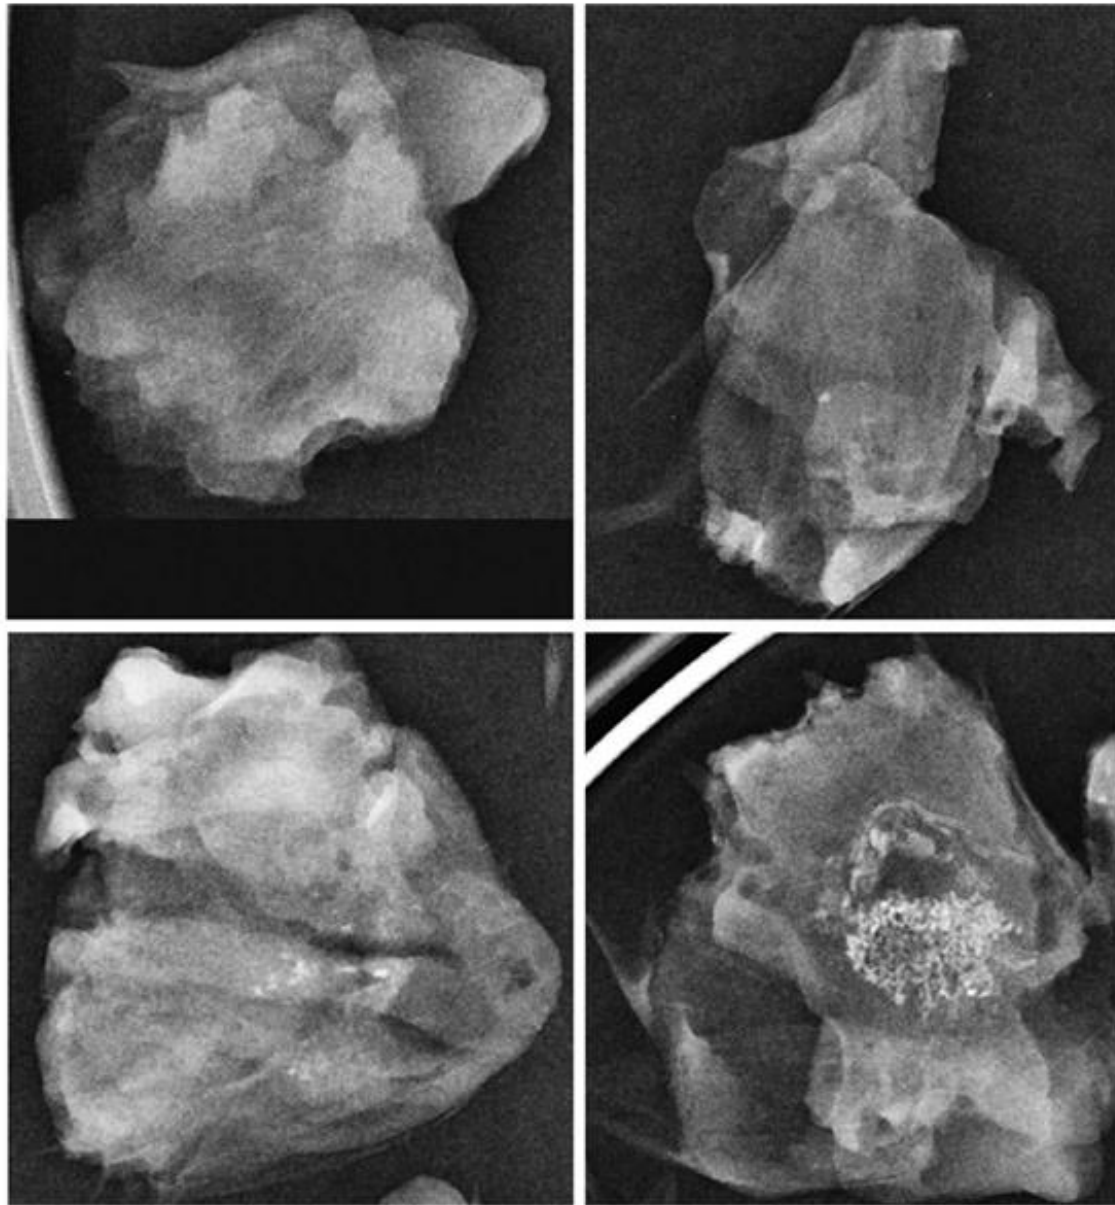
Radiographic patterns taken by means of mammography (with magnification; focus, 0.1 mm). (Above, left) Calcium deposits not seen. (Above, right) Pointed calcified lesion. (Below, left) Several pointed calcified lesions. (Below, right) Calcium plaque.
